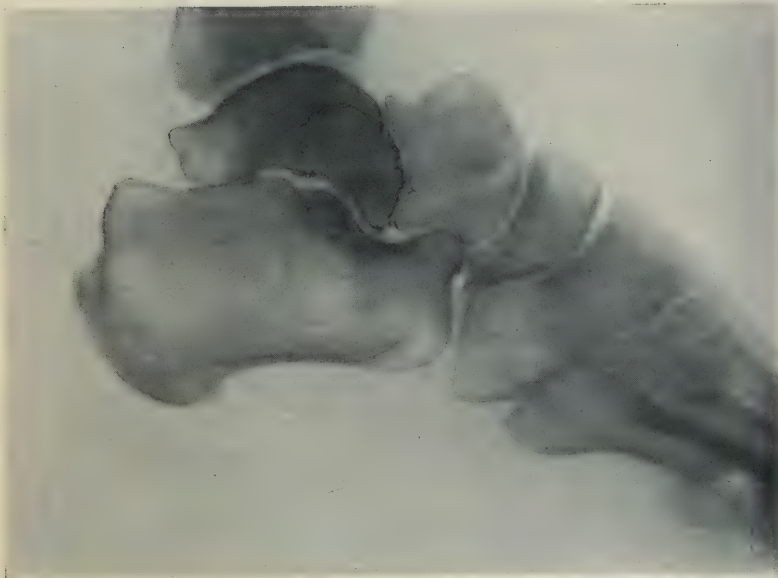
Fracture of the astragalus. Patient fell ten feet to ground, September, 1900. "Sprained ankle." X-ray, fracture of neck of right astragalus.
